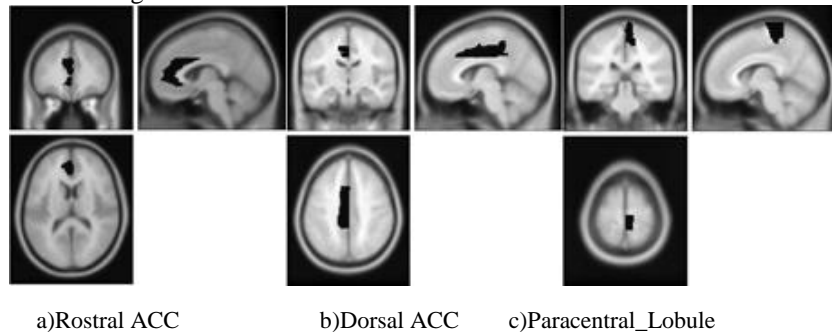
Spatial localization of chosen regions of interest, superimposed on the T1-weighted MNI template.
